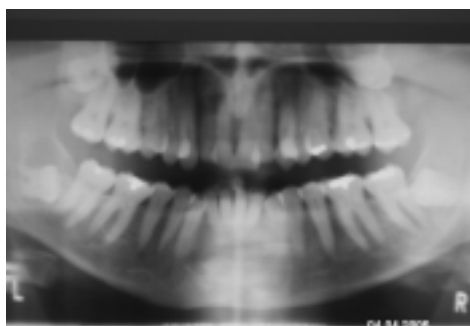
Preoperative panoramic radiograph demonstrating pathology associated with tooth #17
